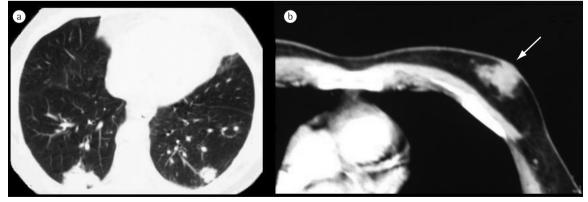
a) Computed tomography of the chest showing the presence of multiple irregular nodules (arrows), which were heterogeneous after endovenous injection of contrast media (consistent with metastases), in both lungs; and b) The imaging shows the rate of soft-tissue attenuation. In the left breast, the soft tissue was permeable and nodular, with irregular borders and fibroglandular content (arrow).
